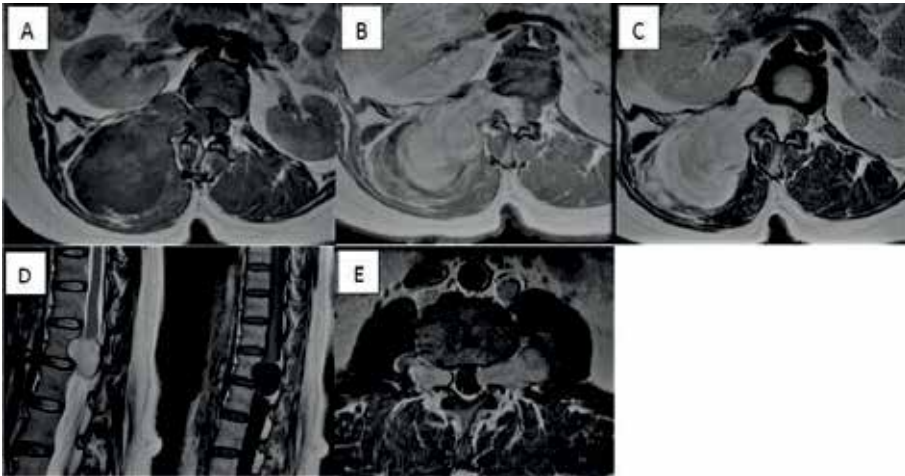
T1W non-contrast-enhanced (A), T1W contrast-enhanced (B), and T2W (C) axial images of a thoracic schwannoma showing cord compression and massive retroperitoneal and paraspinal component. Midsagittal T1W and T2W MR images of a patient with thoracic schwannoma (D). Axial T2W MR image of a syndromic patient with NF1 showing bilateral spinal neurofibroma (E).
